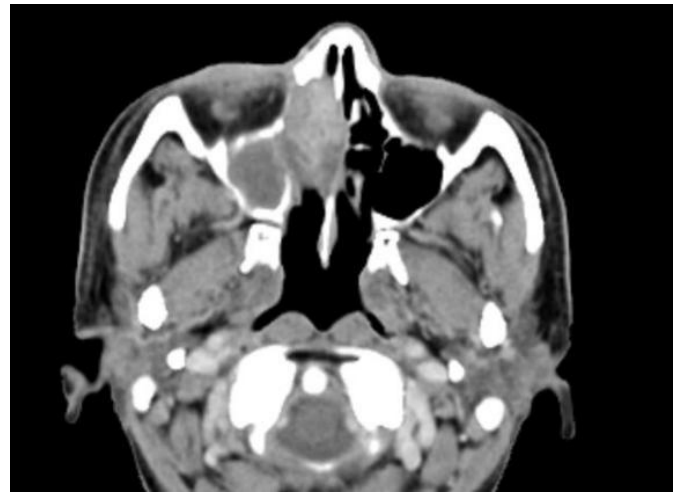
CT PNS with contrast shows soft tissue lesion in the ethmoid sinus extending into right maxillary sinus with erosion of the right maxillary ostia.
